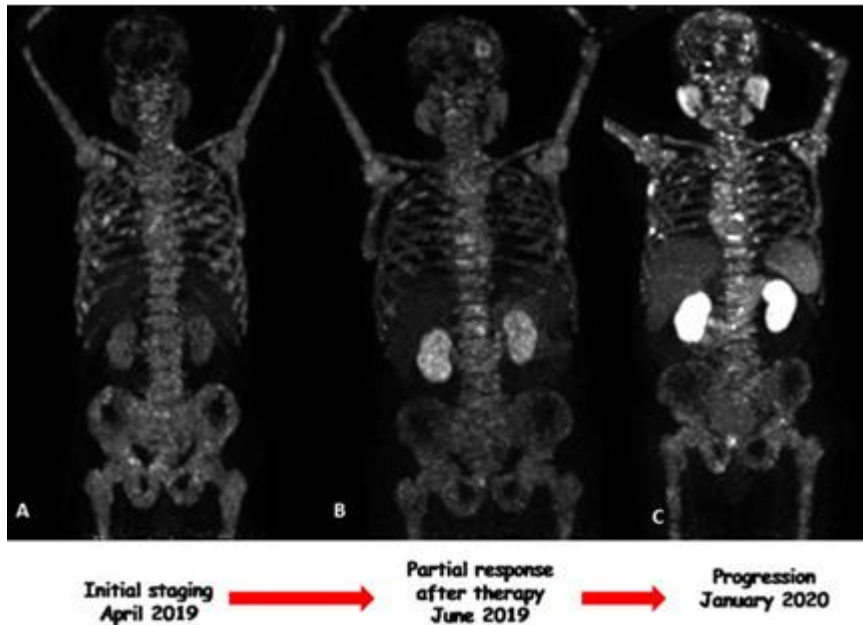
Superscan patterns on serial Ga-68 PSMA images with changing uptake values after therapy of the same patient on first line image (A), posttherapy (B) and restaging (C)
